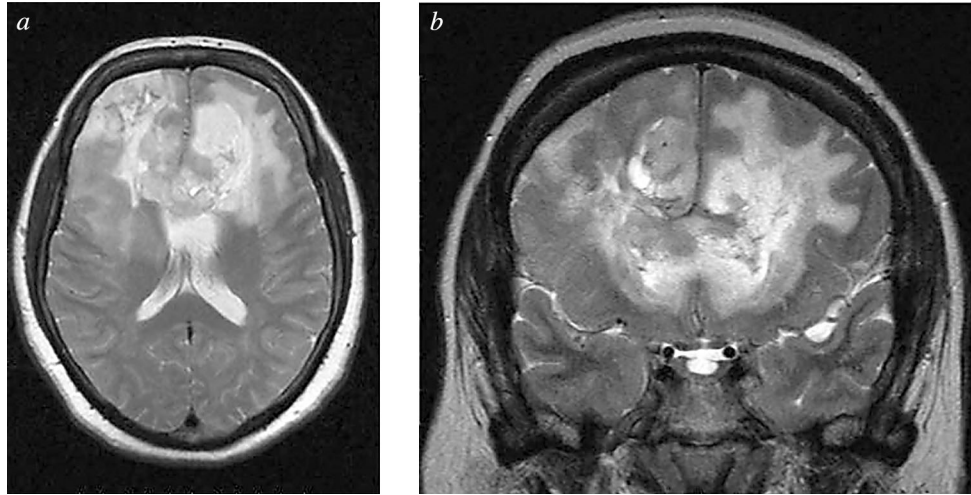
Patient M, female, age 65 years. Diagnosis: anaplastic oligodendroglioma of right frontal lobe with growth through the corpus callosum to the left frontal lobe. Clinically no epileptic seizures. Pathological MRI signal defined an extensive zone of pathology of irregular shape in the frontal lobes on both sides with extension through the genu of the corpus callosum, with inhomogeneous hyperintensity on T2-WI (a, b).
